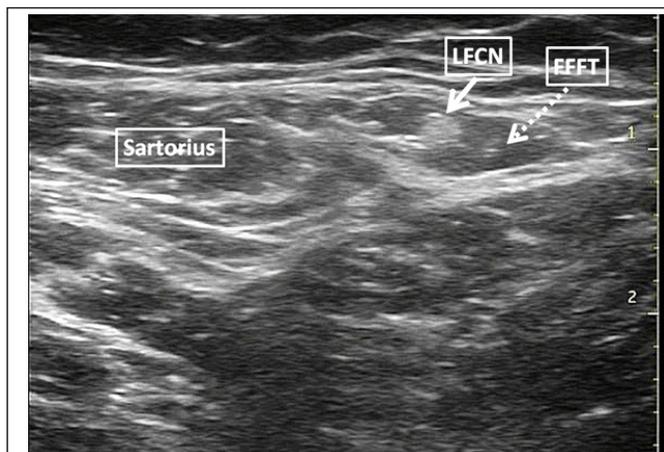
Sonographic anatomy showing The LFCN, the LFCN canal (Fat-Filled Flat Tunnel, FFFT).
